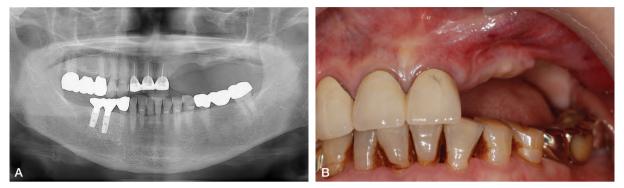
A: Panoramic radiograph before re-implantation(2014/09) B: Intraoral photograph(2014/10)
